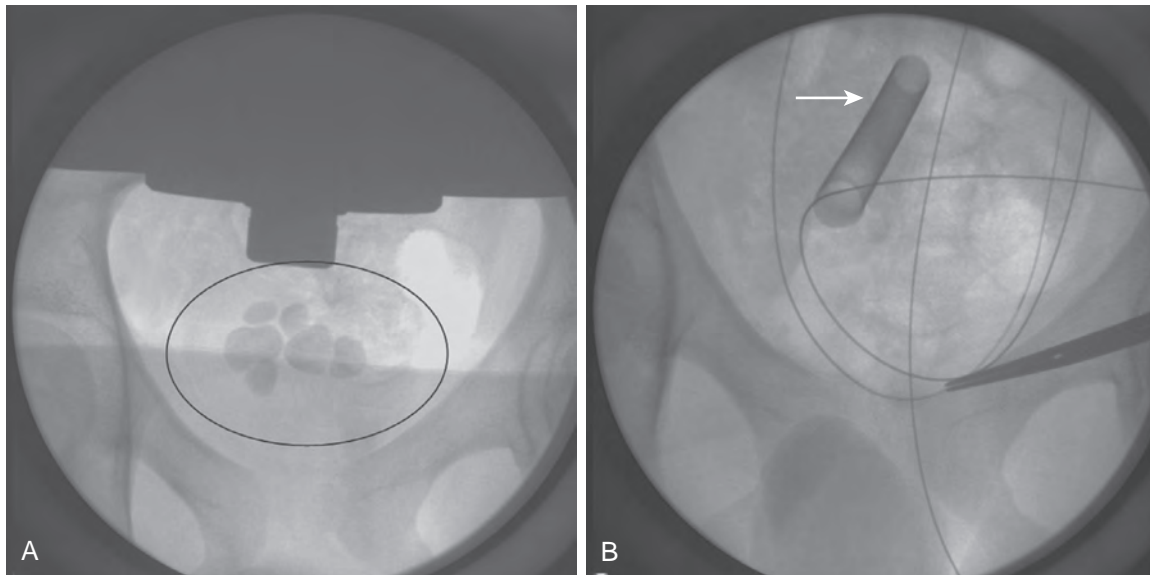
A 12-year-old boy with spina bifida with an augmented bladder (ileocystoplasty) found to have multiple sizeable bladder stones (A) on a workup for recurrent *Proteus mirabilis* infections. B, Percutaneous cystolithotripsy with an ultrasonic lithotripter was performed through a 30-Fr access sheath (arrow), clearing all stones from the augmented bladder.
